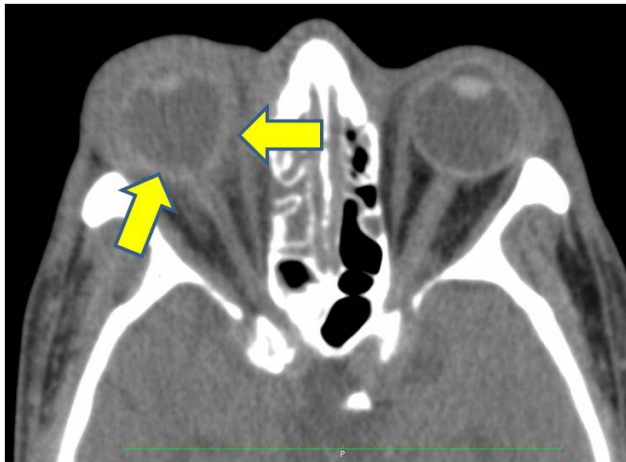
a/b: Axial CT in a different patient: note the shape of the globe is distorted like a "shape of guitar pick". This is a signs of extensive orbital disease with increase in intra orbital pressure – note the proptosis, increase in orbital fat density, preseptal edema and sinusitis.
